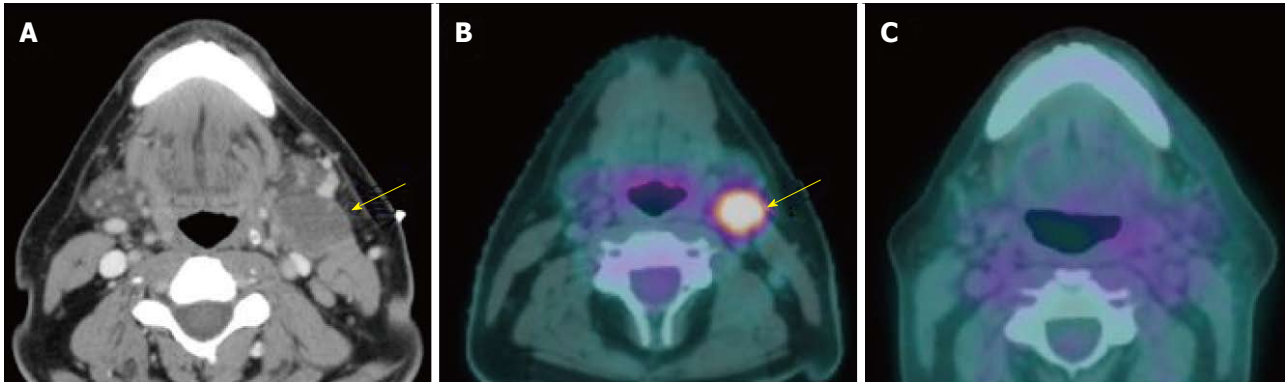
Complete response of metastatic cervical lymph node. Left level IIa metastatic lymphadenopathy (arrows) from the same patient in Figure 3 with squamous cell carcinoma of the left palatine tonsil was identified on both contrast-enhanced CT (A) and pre-treatment PET/CT (B) with maximal SUV: 12.1. After treatment, the lymph node was no longer hypermetabolic at 10-wk PET/CT (C) with maximal SUV: 2.5, representing complete response. PET/CT: Positron-emission tomography/computed tomography; SUV: Standardized uptake value.
